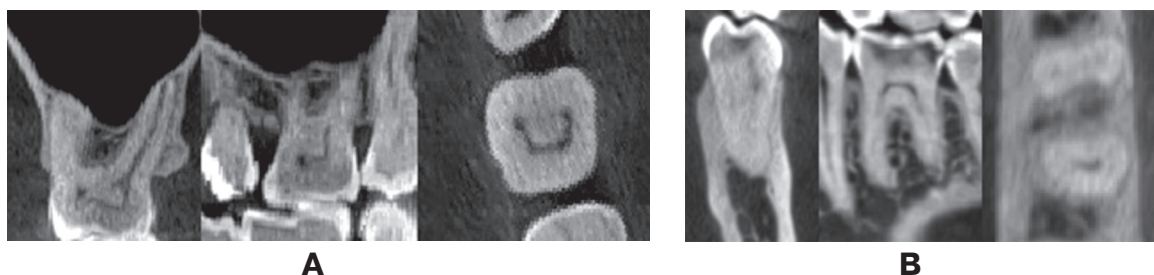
CBCT-image (axial, frontal, sagittal view): A – maxilla first molar with calcification; B – mandible first molar with partial obliteration
